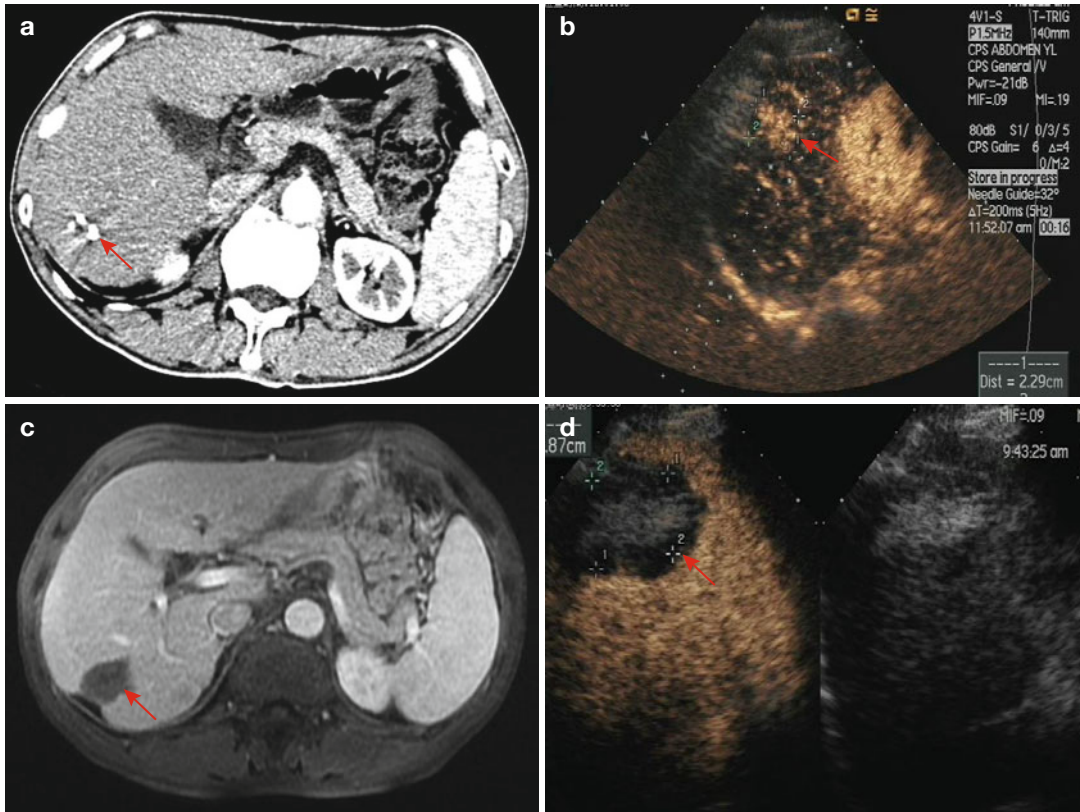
Images in a 56-year-old man who underwent CEUS guidance MWA with a 2.4×2.3 cm local residual lesion of HCC after TACE. (a) Contrast-enhanced CT shows a local residual lesion in the right hepatic lobe after TACE (arrow). (b) Conventional US could not detect the tumor, but the CEUS shows arterial phase adjacent to the TACE zone indicative of local residual lesion (arrow).
